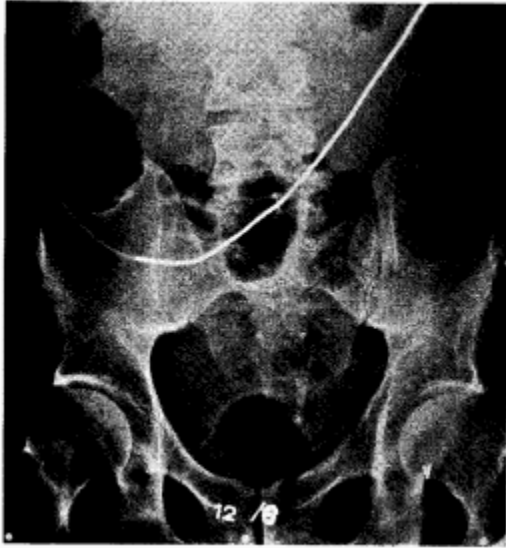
X-ray of the catheter guide bent to form a slight curve and introduced into the catheter. Its end lies near the tip of the catheter.
